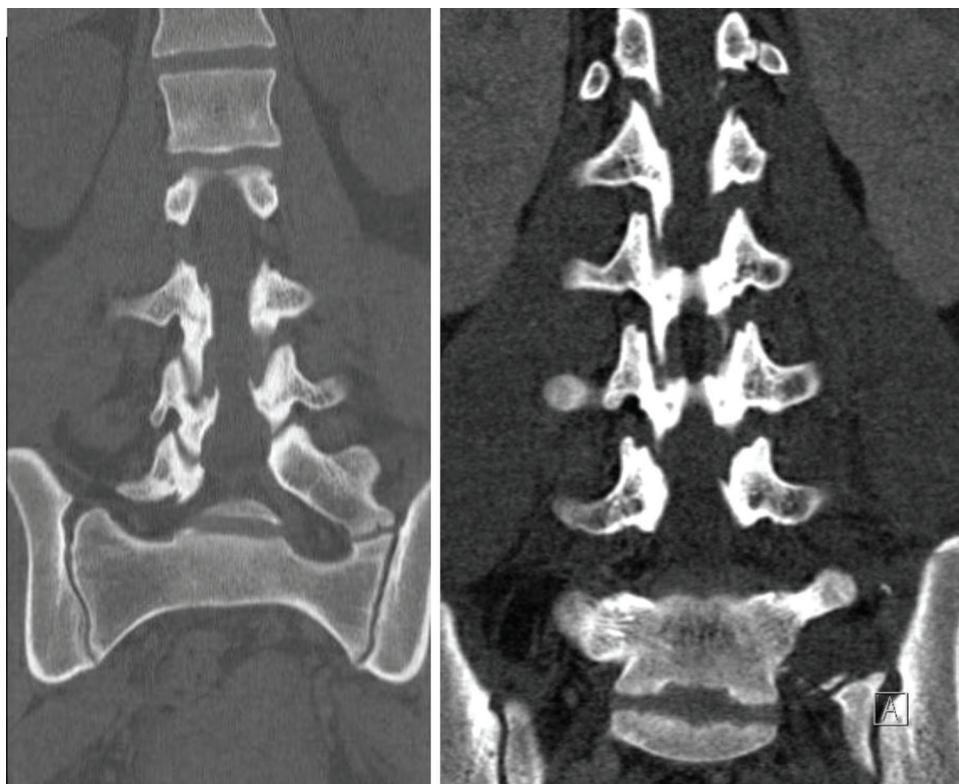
Coronal computed tomography (CT) scans of the lumbar spine showing: Left type IIa LSTV (Left) and postoperative pseudoarthrosis resection of a Left type IIa LSTV (Right).
